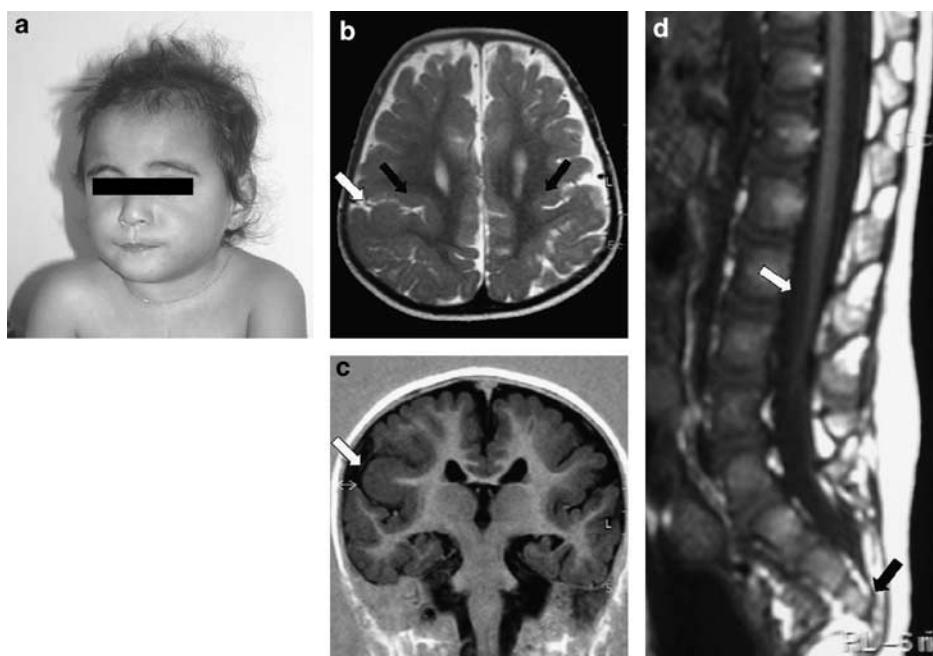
Clinical and neuroradiological aspects. (a) Facial appearance at age 3. (b) MRI: coronal section (T2), note normal gyral pattern. (c) MRI: frontal section (T1), bilateral opercular dysplasia and unilateral (right) pachygryia. (d) Sagittal MRI section of dorso-lumbar spinal canal disclosing tethered spinal cord.
